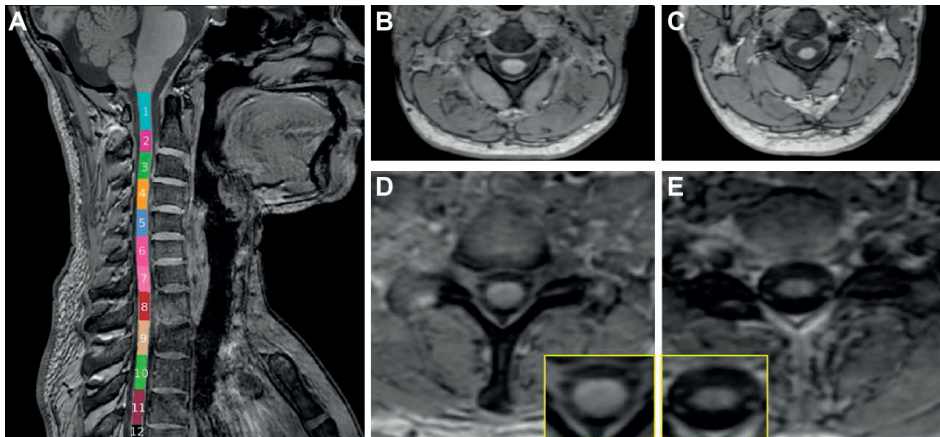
Structural MRI of the spinal cord
